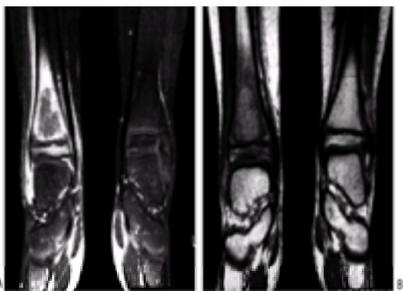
A: T1 MRI of the distal tibia in an 11-year-old female with right ankle pain and limp. She was started on oral antibiotic, but failed to resolve. The MRI demonstrates the edema in the distal right tibia, compared to the normal marrow signal from the left tibia. B: The spin echo postcontrast T1 images show enhancement due to the contrast material, and the absence of the bright fat signal. Note the center of the lesion, which suggests abscess formation.
